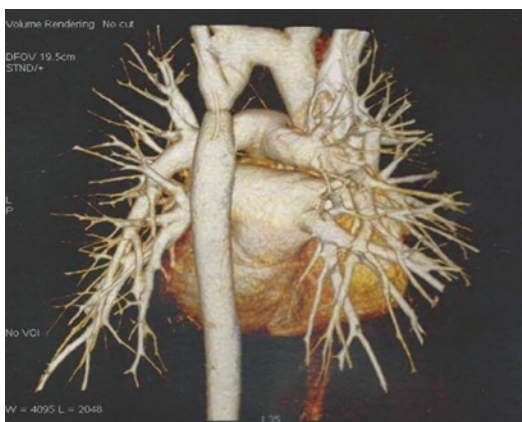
CT angiography of the thoracic aorta, showing coarctation area of the descending thoracic artery next to the emergence of the subclavian artery to the left
